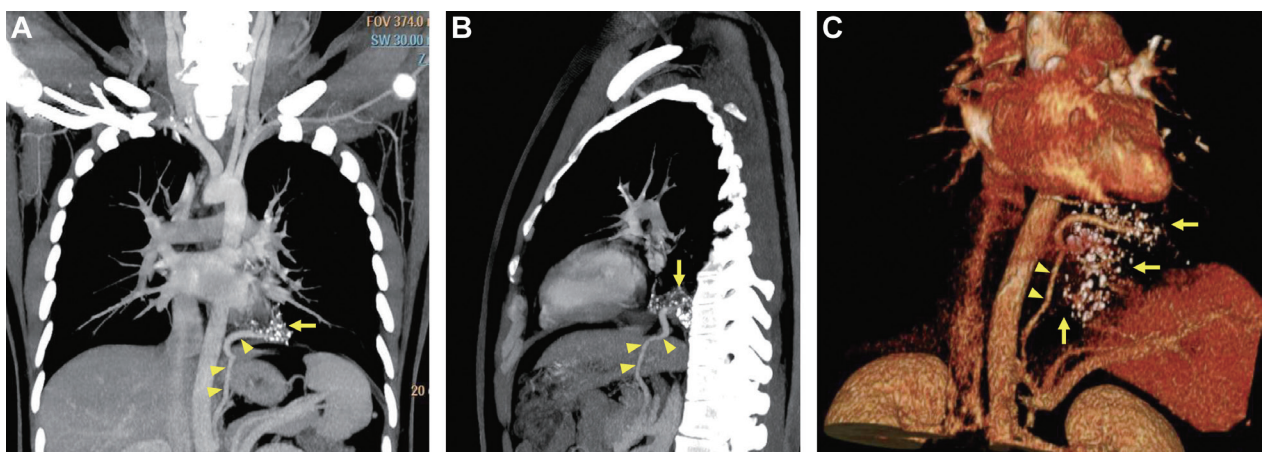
Computed tomography (CT) of the chest with contrast enhancement disclosed intralobar pulmonary sequestration in the left lower lobe (arrows) with an aberrant feeding artery (arrowheads) arising from the celiac trunk. (A) Coronal view; (B) sagittal view; (C) reconstruction CT angiography.
